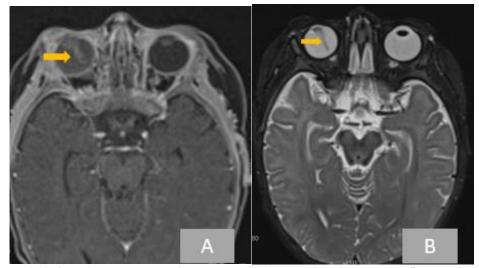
Figure 1: Axial T1 contrast material—enhanced (A) abd T2-weighted (B) 1.5-T MR image; A funnelshaped extending from posterior segment extending from the posterior lens surface to the optic disc (arrow). The lens has abnormal morphology compared with the normal left lens. Contrast enhancement to indicate an intraocular tumour is evident
